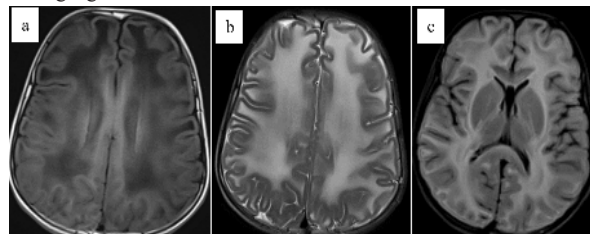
a), b) and c) T1W hypointensity and T2W/FLAIR diffuse hyperintense signals in bilateral cerebral hemisphere white matter with sparing of basal ganglia.
